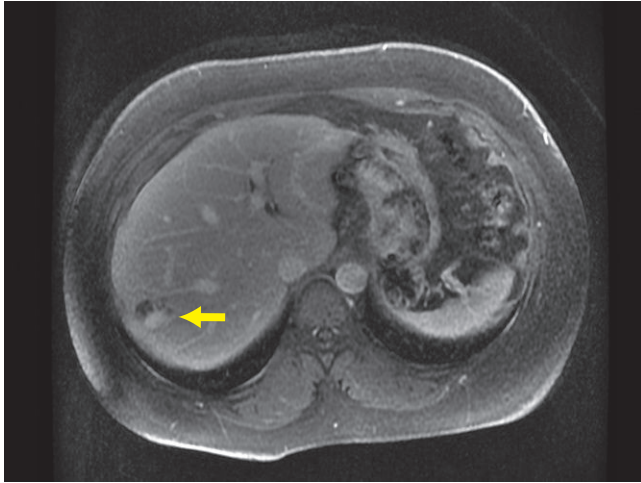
Delayed contrast-enhanced MRI shows a nodular rim of enhancement (arrow).
